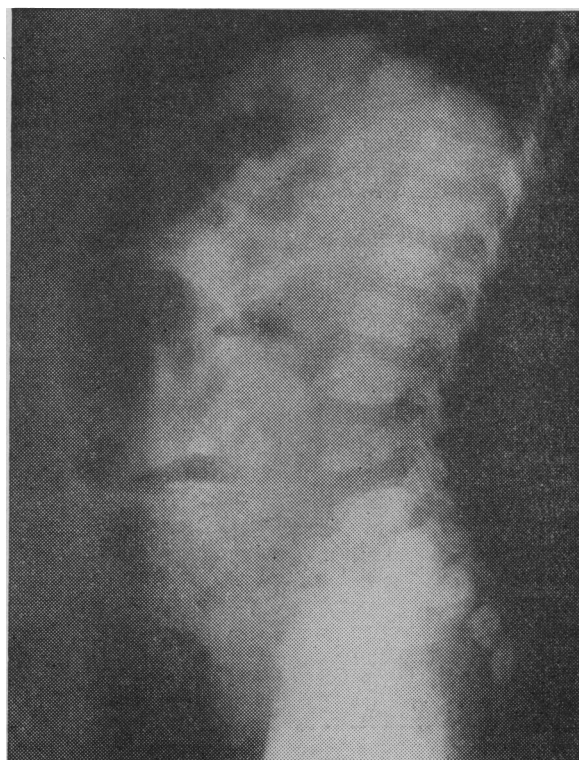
Lateral x-ray film of abdomen showing calcification, dilated loop of small gut, and fluid levels.
